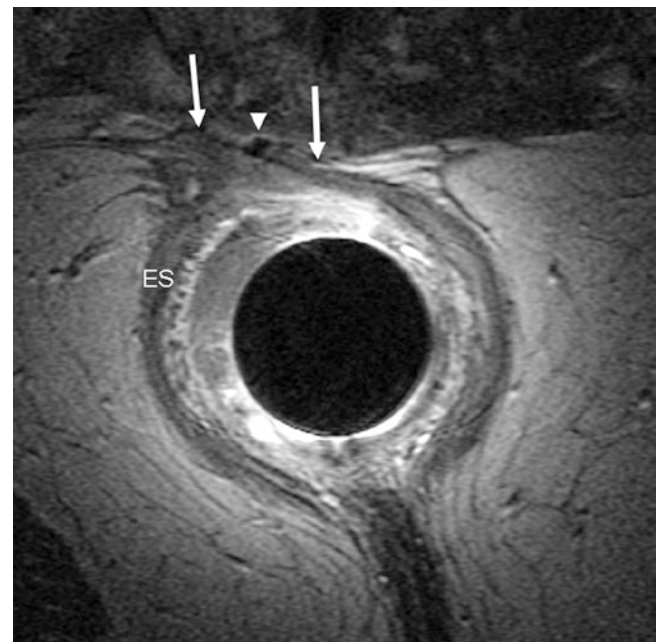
Endoanal axial T₂-weighted turbo spin-echo in a 34-year-old female patient with fecal incontinence. She had a complete rupture 4 years earlier and underwent anterior anal repair for an anterior external defect at EAUS. Fecal incontinence had not improved after anterior anal repair. At endoanal MRI there is reasonable left-over-right overlap of the external sphincter parts (arrows). There is some atrophy of the external sphincter. Susceptibility artifact anterior (arrowhead). ES external anal sphincter
